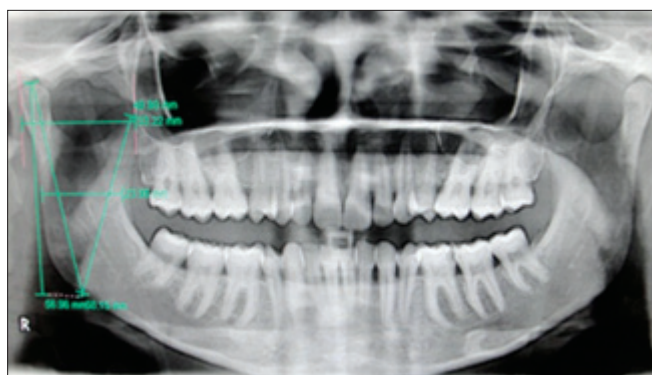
Measurements of mandibular ramus on orthopantomograph
